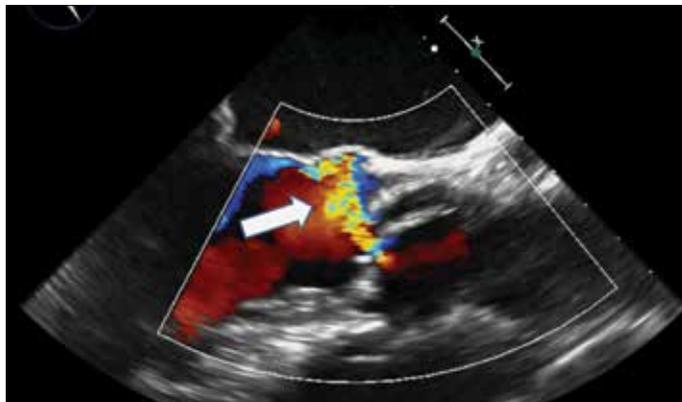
Transesophageal echocardiogram showing aortic regurgitation jet (White Arrow) pointing directly towards the site of perforation of mitral leaflet
